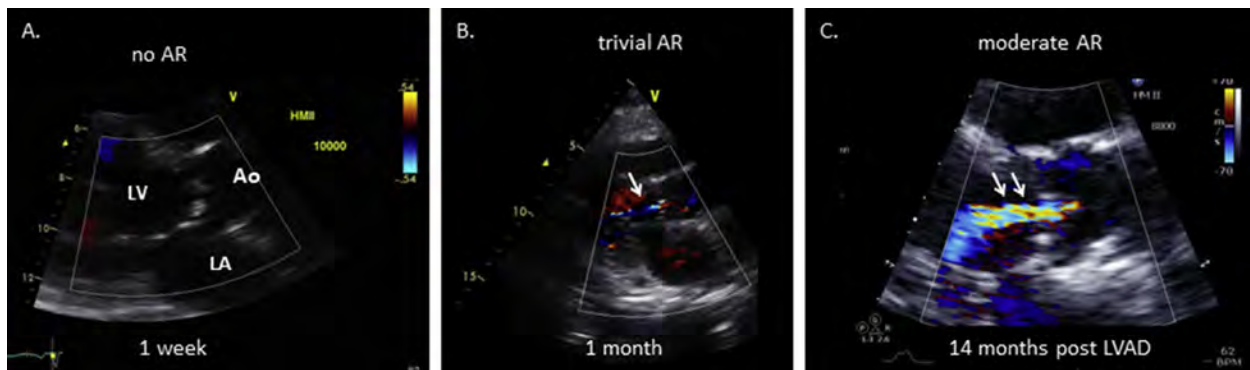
De novo AR after LVAD implantation. This condition progressed from no AR on the baseline surveillance study exam at 1 week (A) to trivial AR (arrow) at 1 month (B), to at least moderate AR (arrows, VC >3 mm) at 14 months (C). All images are transthoracic parasternal long-axis views with color Doppler. In this patient, the AV never opened at any pump speed during the LVAD support period; aortic root thrombus was not present. See also [Videos 24-26](#).
